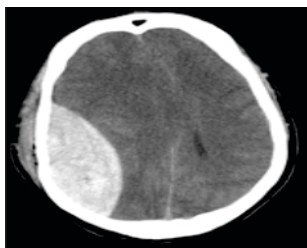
CT Scan In Patient With EDH: Biconvex Shaped
